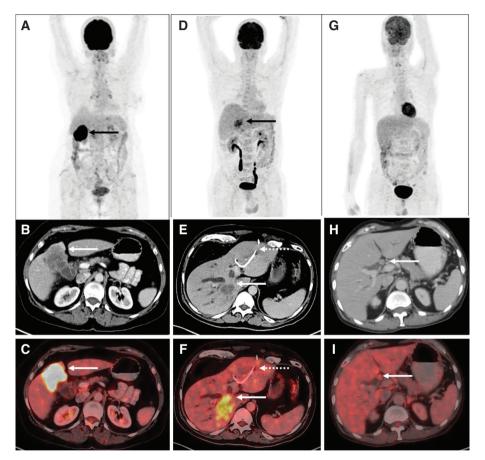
¹⁸F-FDG PET/CT in biliary tract cancers: A) Maximum Intensity Projection (MIP) image showing focal intense tracer uptake in the region of the gallbladder fossa (black arrow). Corresponding CT (B) and fused PET/CT (C) images show intensely tracer avid (SUVmax 28.7) heterogeneously enhancing mass lesion arising from the fundus and body of the gallbladder with local invasion (Gallbladder carcinoma) (white arrows). D) MIP image showing tracer uptake in the region of the liver (black arrow) with corresponding CT (E) and fused PET/CT (F) images showing tracer uptake in the region of the liver (black arrow) with corresponding CT (E) and fused PET/CT (F) images showing ¹⁸F-FDG avid (SUVmax 11.2) hypodense lesion in the right lobe of liver (white arrows) causing intrahepatic biliary radical dilatation suggestive of intrahepatic cholangiocarcinoma along with percutaneous transhepatic biliary duct stent in situ in the left ductal system (dotted arrow). G) MIP image with no abnormal focus of uptake seen anywhere in the region of the liver. (SUVmax 5.1) in the hilar region with tracer uptake similar to background liver uptake suggestive of hilar cholangiocarcinoma.
